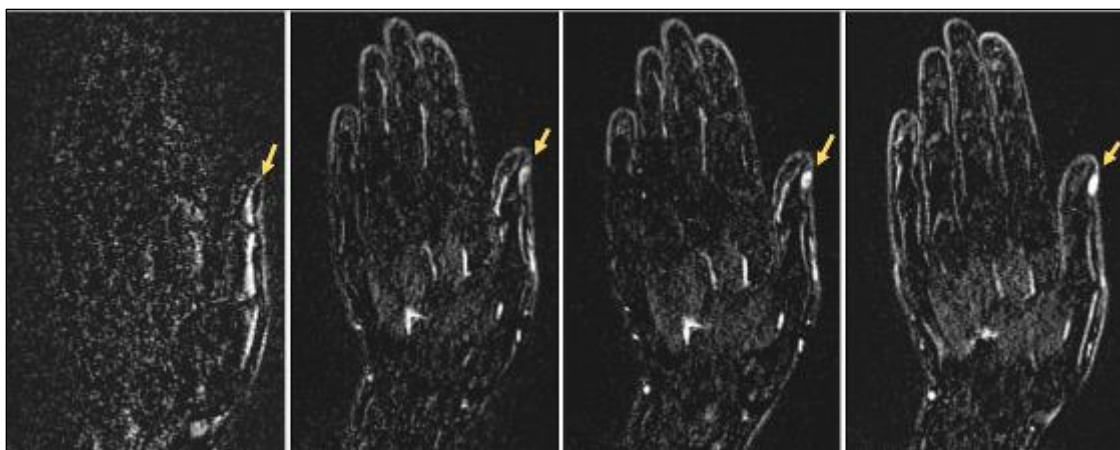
Subtracted dynamic contrast-enhanced MRI of the hand. Successive dynamic phases from left to right: the subungual lesion of the thumb shows early, intense, and progressive enhancement (arrows). *MRI, magnetic resonance imaging*
